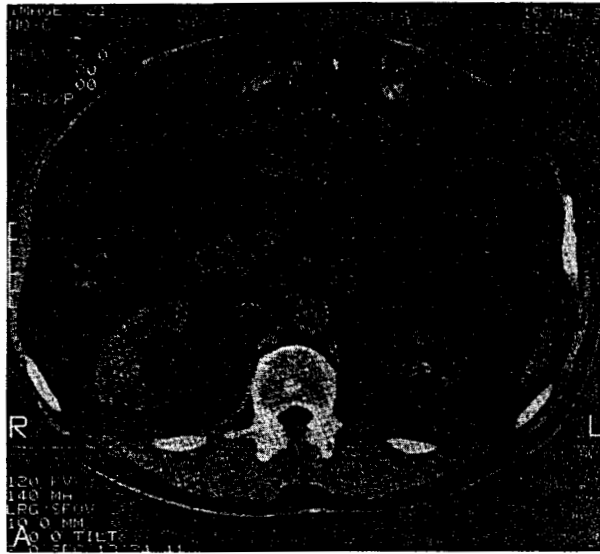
Computerized axial tomography (CT) scan. *A*, Demonstrating thickened gastric folds and increased secretions in stomach (supine position). Gastrinoma is seen as circular mass anterior and to left of aorta. *B*, Magnetic resonance imaging (MRI) study demonstrates enormously thickened gastric wall in the same patient.
